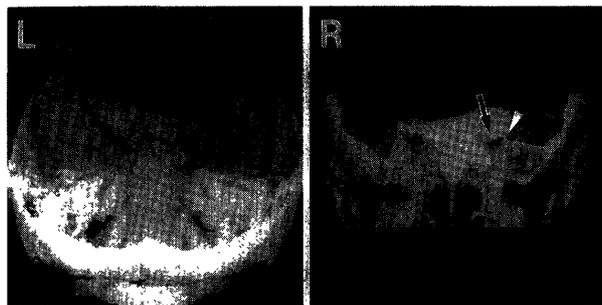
Preoperative 3D-CT scans showing narrowing of the optic canal (*arrow*) and the superior orbital fissure (*arrowhead*), and enlargement of the left anterior clinoid process and the planum sphenoidale. Abnormal proliferation of bony tissue is seen in the ethmoid sinus.
